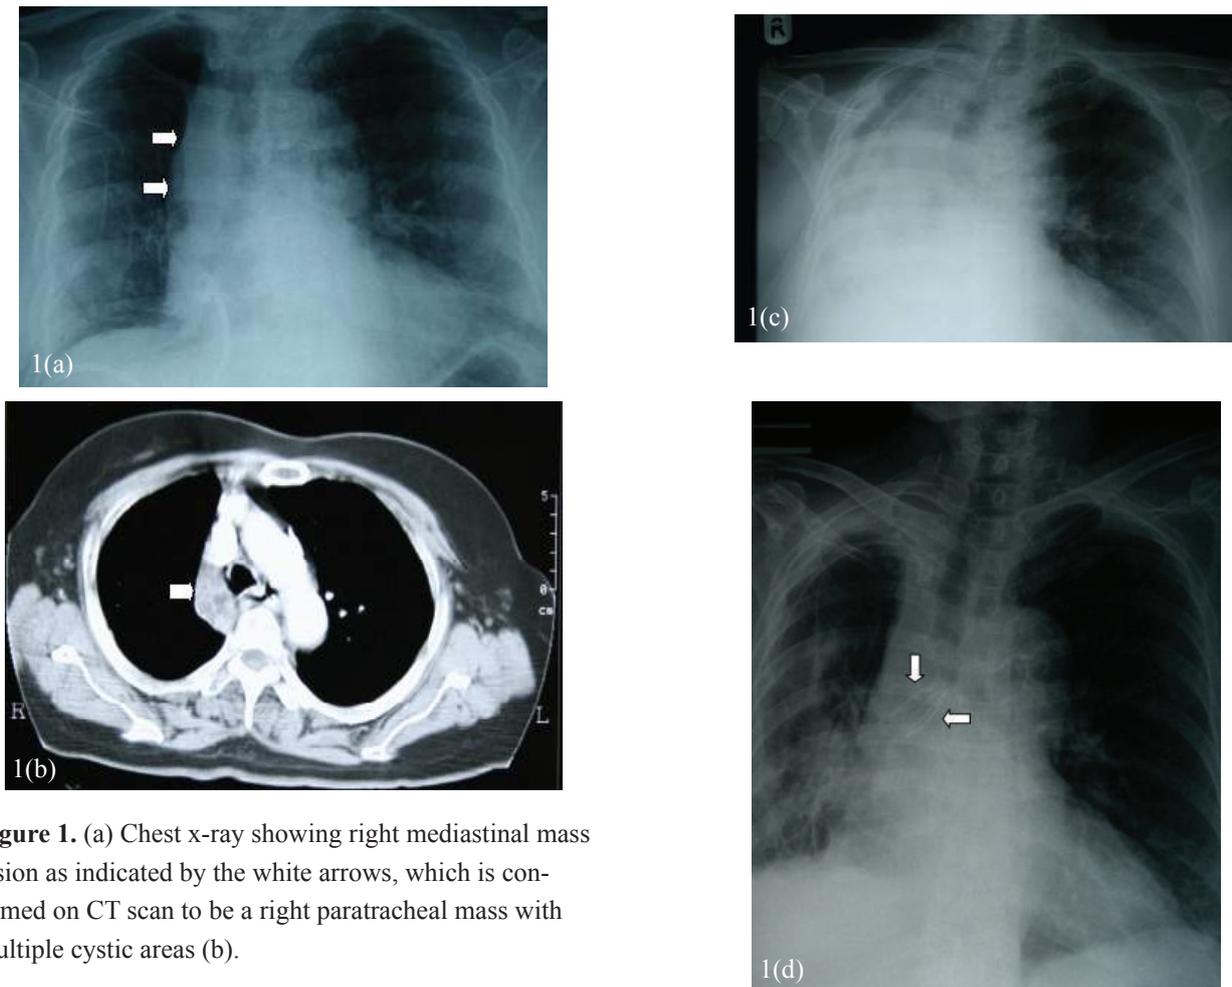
(a) Chest x-ray showing right mediastinal mass lesion as indicated by the white arrows, which is confirmed on CT scan to be a right paratracheal mass with multiple cystic areas (b).
